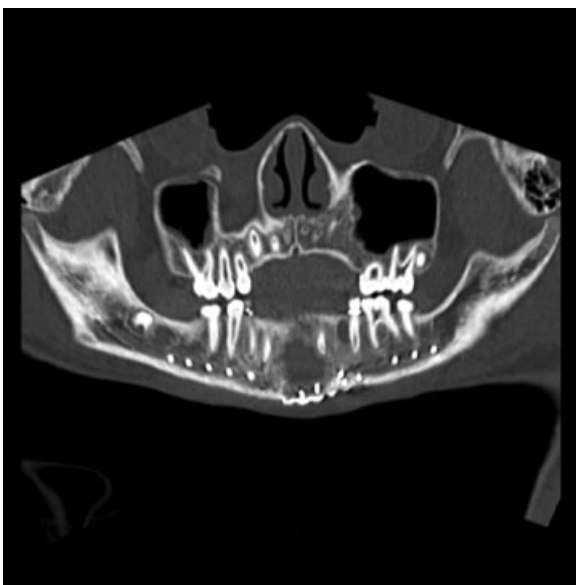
Panorex computed tomography scan obtained 7 weeks postoperatively demonstrating improved anatomic alignment with some neo-osteogenesis and persistent cystic defect of the mandible.
